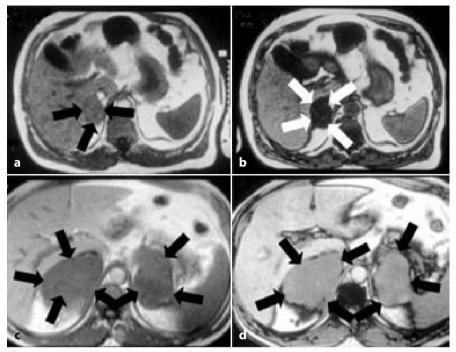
MRI differential diagnosis of adrenocortical adenoma and adrenocortical carcinoma using the "chemical-shift" method. a A left benign neoplasm sharing a positive chemical shift is shown. In the "out of phase" sequences, the signal intensity of the neoplasm (*white arrows*) is typically lower than that of the spleen, different from what happeoccursn in the "in phase" image (b) (*black arrows*), where their grayscale aspect is similar. On the left the mass seems to be darker and it is therefore more readily recognizable. Reduction of signal intensity >20%, is almost pathognomonic of a benign lesion. In c and d, the signal intensity of a bilateral, large adrenal incidentaloma does not significantly change from in phase to out of phase acquisitions. This phenomenon is called a "negative chemical shift" and suggests an adrenocortical carcinoma
